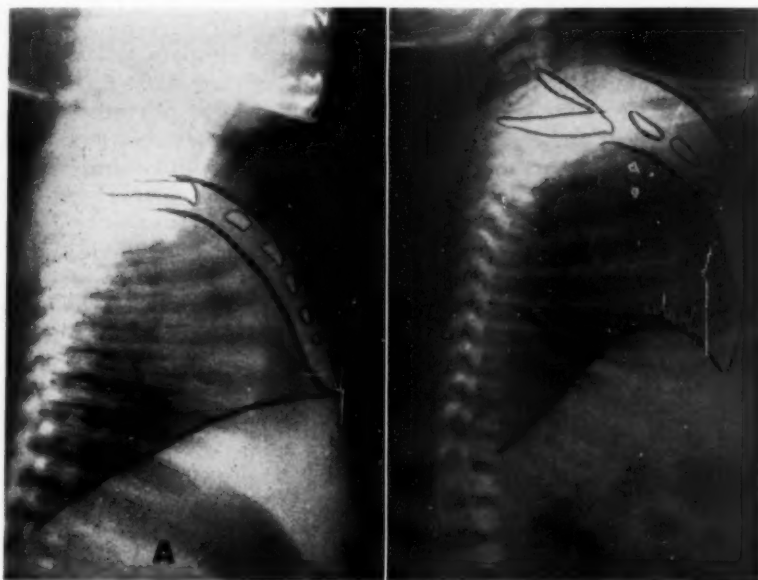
Retouched roentgenograms showing five ossification centers in the sternum of Baby Girl D. No. 1 (A) and only three in Baby Girl D. No. 2 (B).
